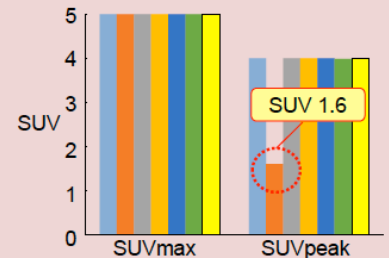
Comparison of SUVmax and SUVpeak between 6 software programs
